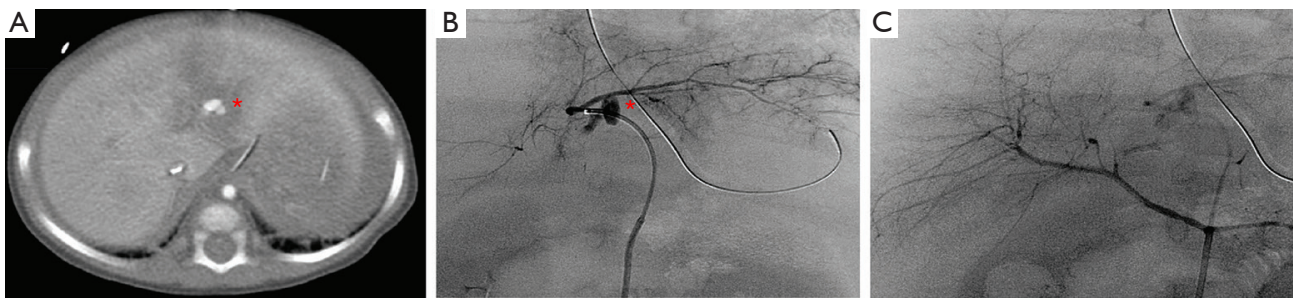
TAE for non-penetrating trauma. (A) Contrast enhanced CT done in an 8 month old victim of non-accidental trauma showed arterial extravasation/pseudoaneurysm formation in the left lobe of the liver (asterisk). (B) Common hepatic angiogram failed to show the extravasation/pseudoaneurysm. (C) Selective left hepatic artery injection via cannulation of an accessory left hepatic artery arising from the left gastric artery showed the site of extravasation(asterisk). This was treated with gelatin sponge slurry embolization to good angiographic effect (not shown). Care was withdrawn due to significant intracranial injuries and the patient unfortunately passed shortly thereafter. Images courtesy of Dr. Keith Quencer. TAE, transarterial embolization.
